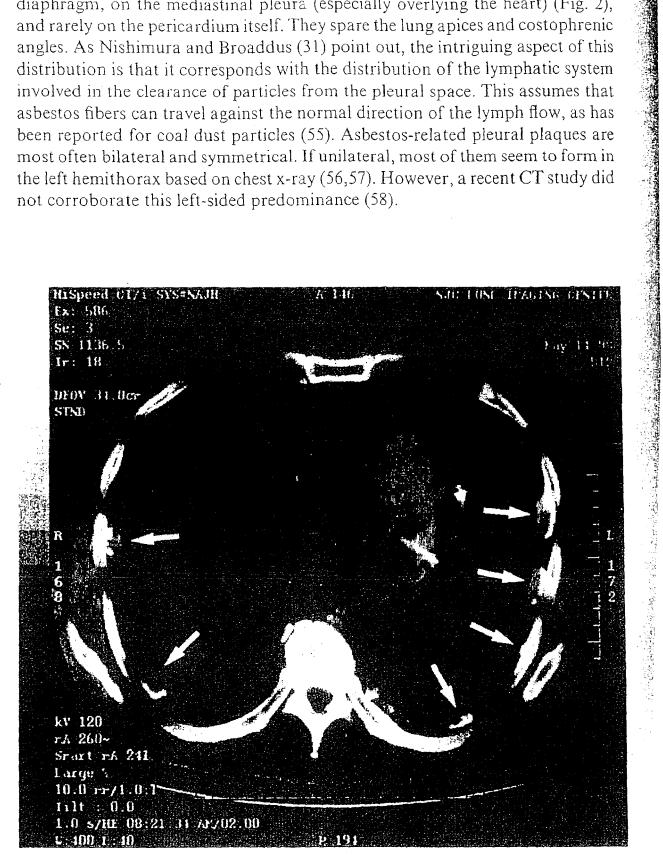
Chest CT with multiple large, localized, partially calcified pleural plaques (white arrows) in classic bilateral distribution along the posterior and posterolateral parietal pleura.
